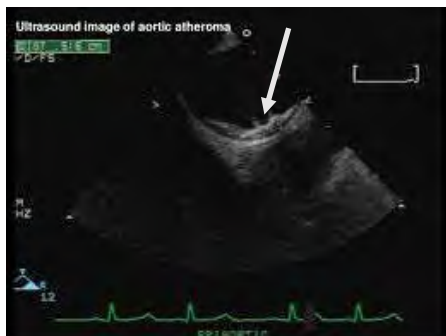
Transesophageal ultrasound reveals the presence of aortic atheroma grade 4 (arrow) (atheroma > 5mm).
